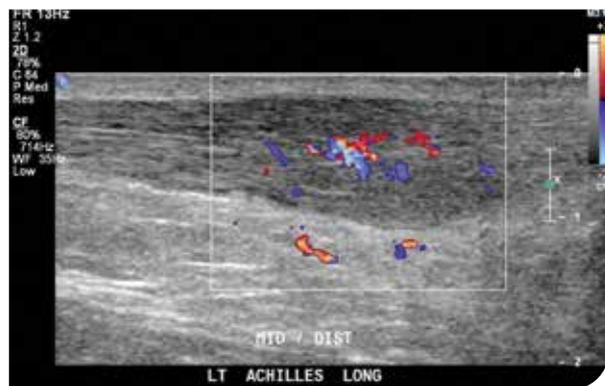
Ultrasound image of a tendon showing fusiform thickening and neovascularity. Image courtesy of Imaging@Olympic Park, Melbourne
